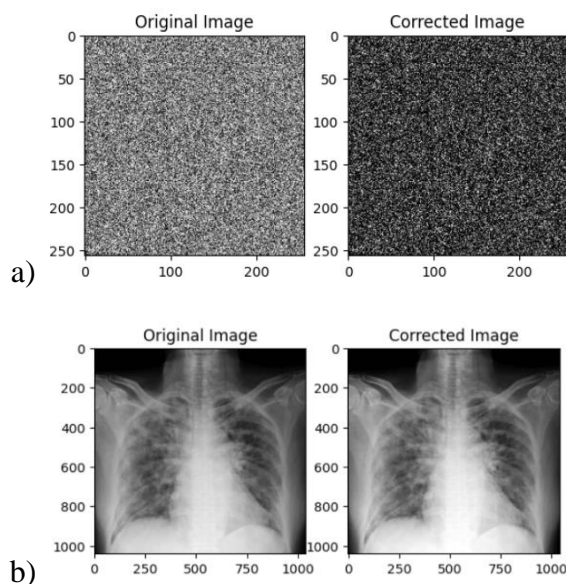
Image processing result before and after applying the response function. a) example of application on a black and white image; b) X-ray image processing before and after applying the filter
